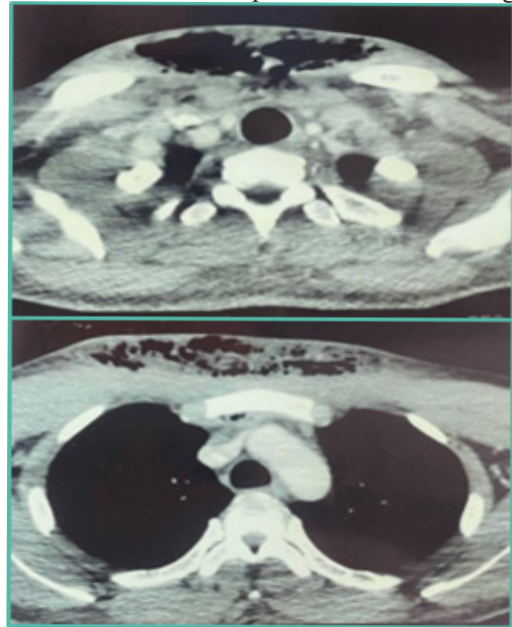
Contrast-enhanced cervico-thoracic CT scan in axial view: cervicofacial cellulitis with mediastinitis (Red arrow).
